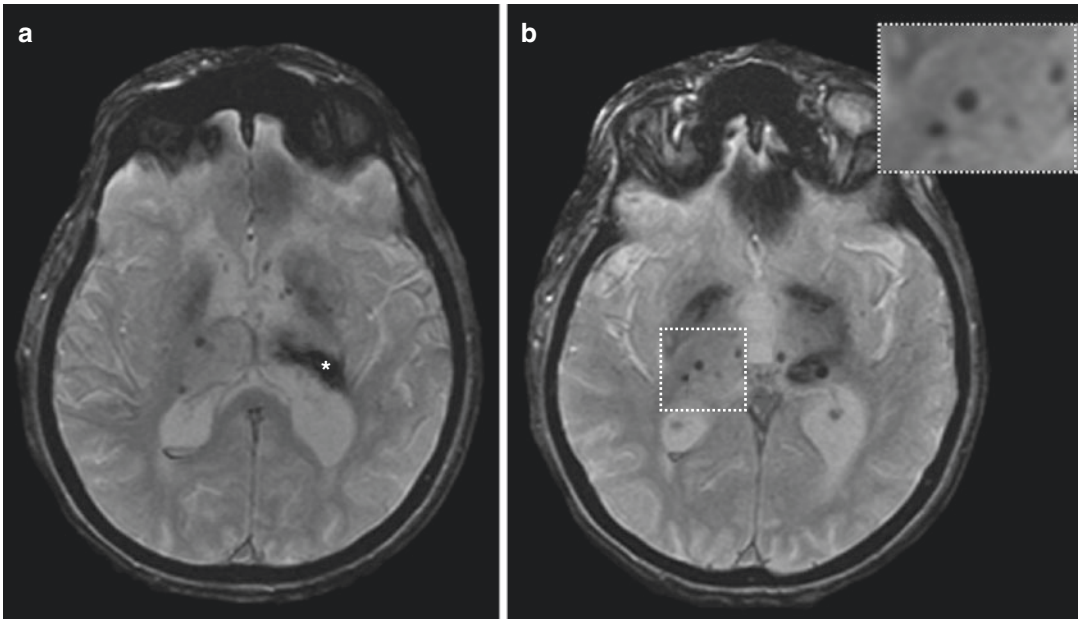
Hypertensive small vessel disease-related intracerebral hemorrhage. T2*-gradient echo MRI sequences in a patient with hypertensive small vessel disease-related intracerebral hemorrhage. Panel a shows a left thalamic
